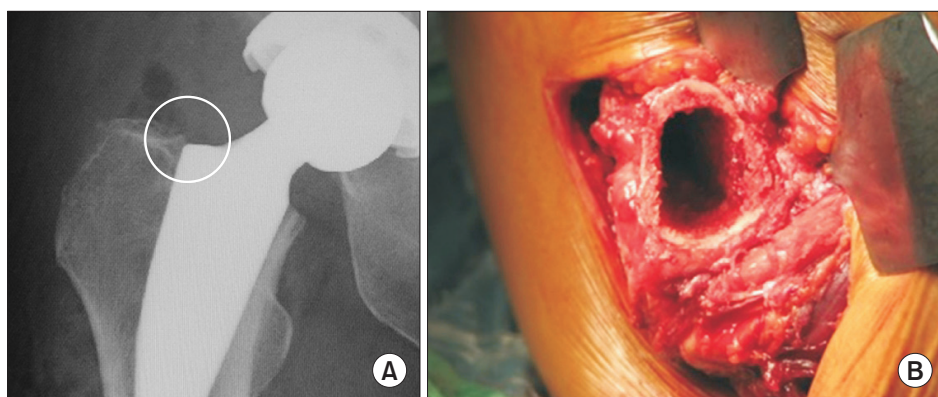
Femoral neck osteotomy for Metha. (A) Postoperative radiograph of proximal femur. Femoral neck osteotomy level was 5 mm above the lowest point on the lateral aspect of the femoral neck (white circle). (B) Intraoperative findings at the osteotomy level. Rasping was performed until the cortical-ring was totally exposed.
